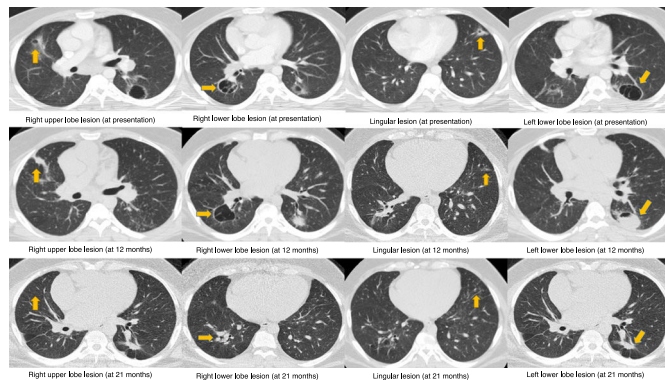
CT scan images showing four representative sections at presentation (first row), 12 months (second row) and 21 months (third row). Arrows indicate the cavitory lesions in the right upper, right lower, lingula and left lower lobes (from left to right).
